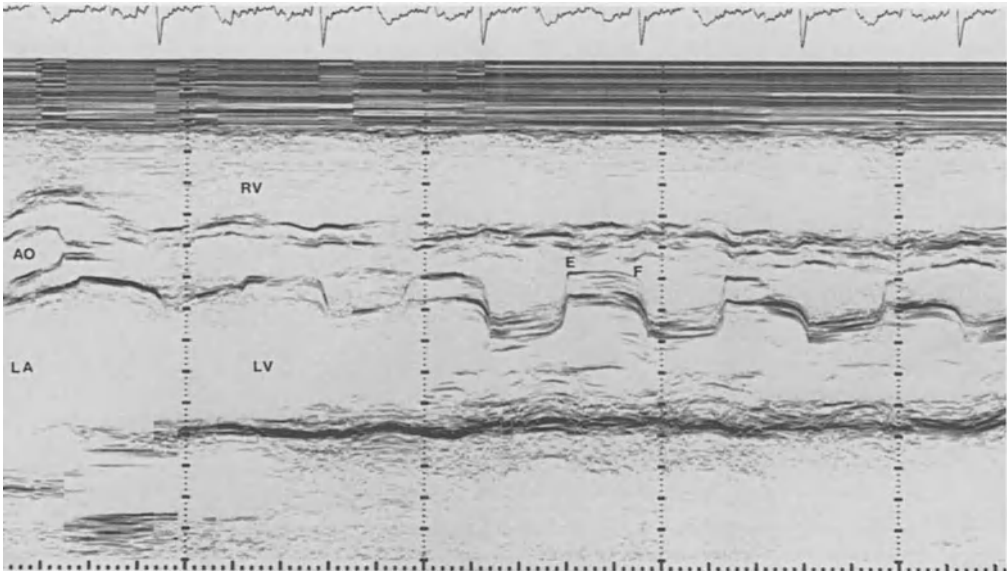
M-Mode echocardiogram showing enlarged left atrium, thickened anterior mitral leaflet with reduced E-F slope.
